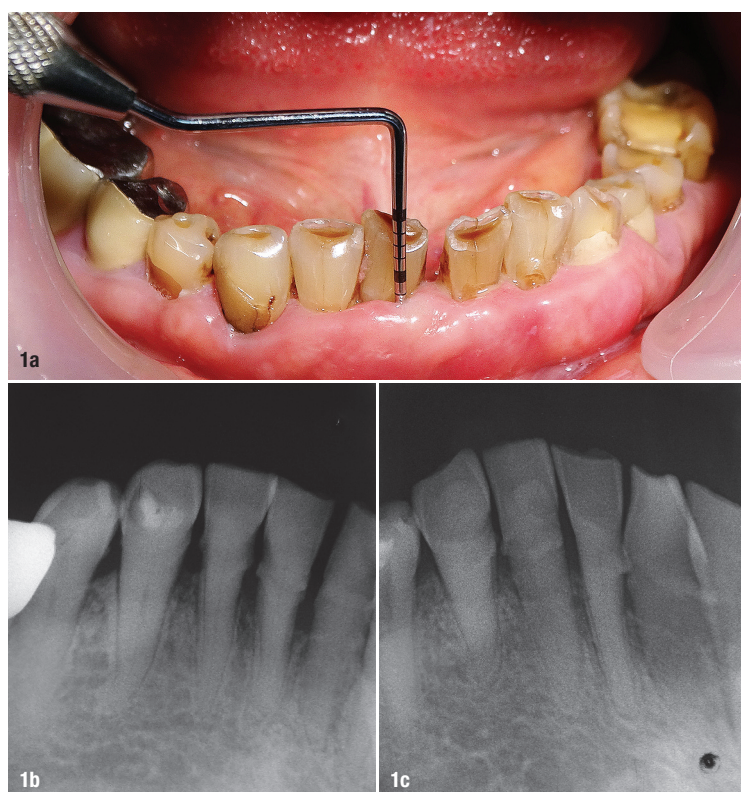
Preoperative view of soft tissues and estimation of periodontal probing depth with a CP-15 probe. Figs. 1b & c: Radiographic evaluation of the mandibular anterior region, showing approximately 2 mm of attachment loss, subgingival calculus and carious lesions.
